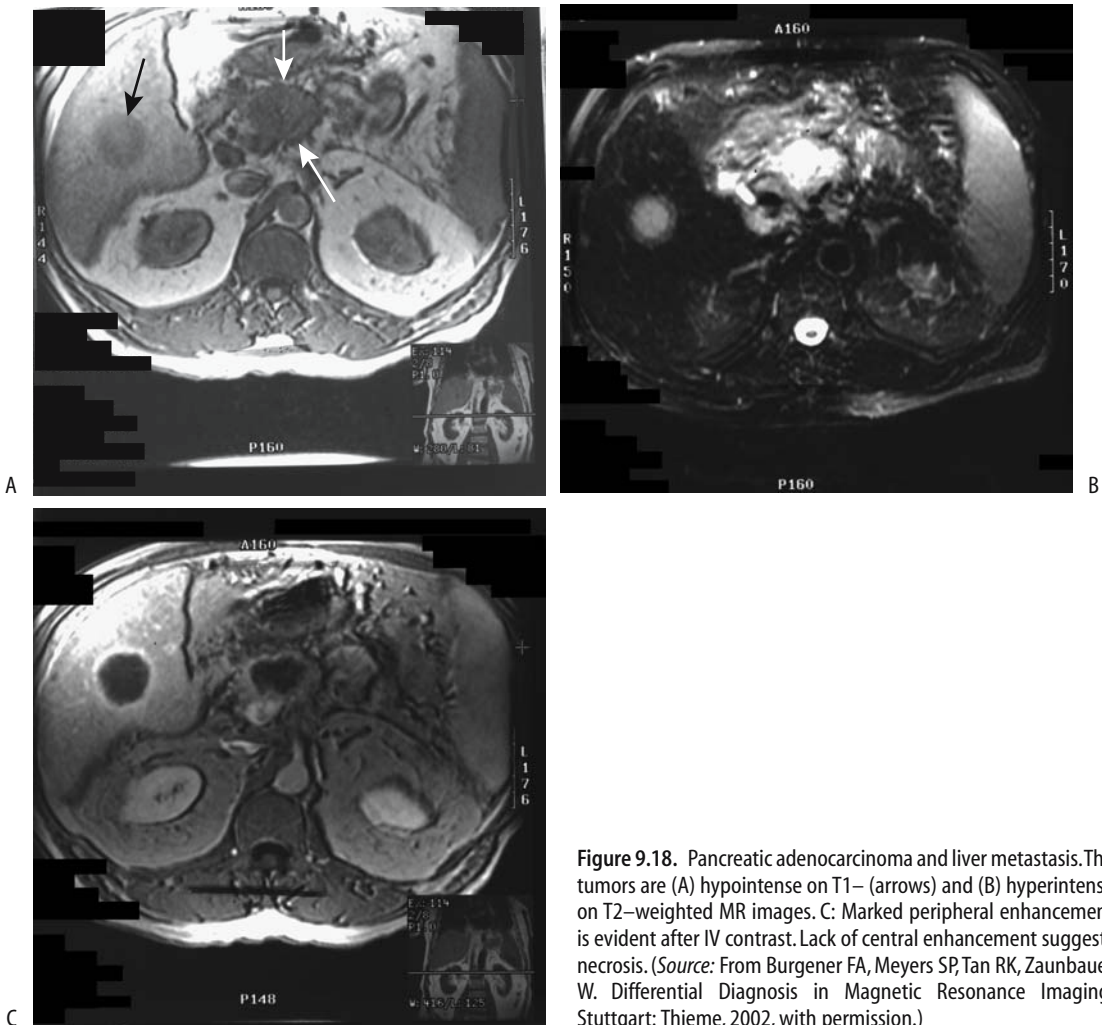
Pancreatic adenocarcinoma and liver metastasis. The tumors are (A) hypointense on T1– (arrows) and (B) hyperintense on T2–weighted MR images. C: Marked peripheral enhancement is evident after IV contrast. Lack of central enhancement suggests necrosis. (Source: From Burgener FA, Meyers SP, Tan RK, Zaunbauer W. *Differential Diagnosis in Magnetic Resonance Imaging*. Stuttgart: Thieme, 2002, with permission.)
